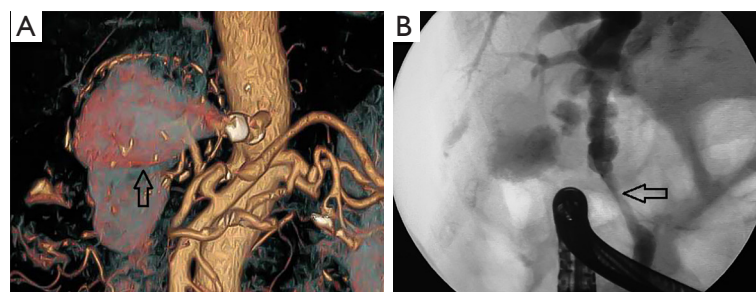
(A) Virtual three-dimensional CT angiography reconstruction demonstrating hepatic artery aneurysm filled with contrast (arrow); (B) endoscopic retrograde cholangiography demonstrating segmental narrowing of the common bile duct due to slight medial compression (arrow) and proximal dilatation of intrahepatic bile ducts. CT, computed tomography.
